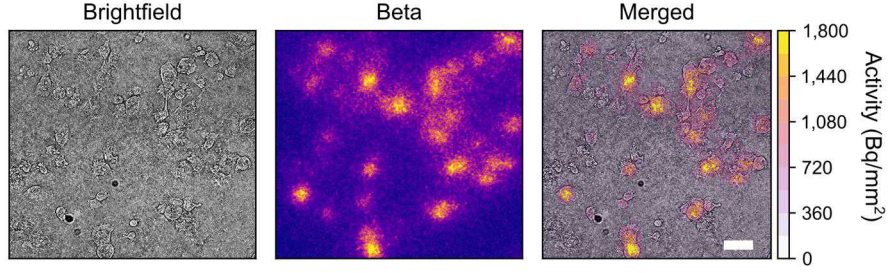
Brightfield (left) and beta (center) imaging of ^{18}F -FDG in breast cancer cells with the LRM setup. The two images can be overlapped for co-localisation (right). The scale bar is $50\text{ }\mu\text{m}$. From [25].
